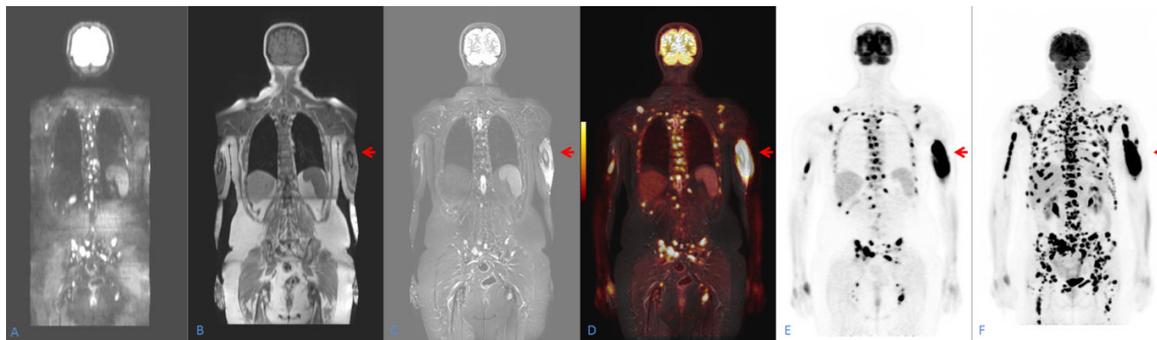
Multiple skeletal myeloma manifestations on coronal DWI (A), T1W (B), TIRM (C), Fused PET/TIRM MR (D), PET images (E), and on 3D Maximal Intensity Projection (MIP) anterior aspect PET dataset (F). Spacious left perihumeral soft tissue mass (red arrow) with inhomogeneous T1 signal (B), high TIRM signal intensity (C) and intensive FDG accumulation respectively (D-E-F). Upper extremities are not visualized on the DWI image dataset as a consequence of smaller available MR field of view.
